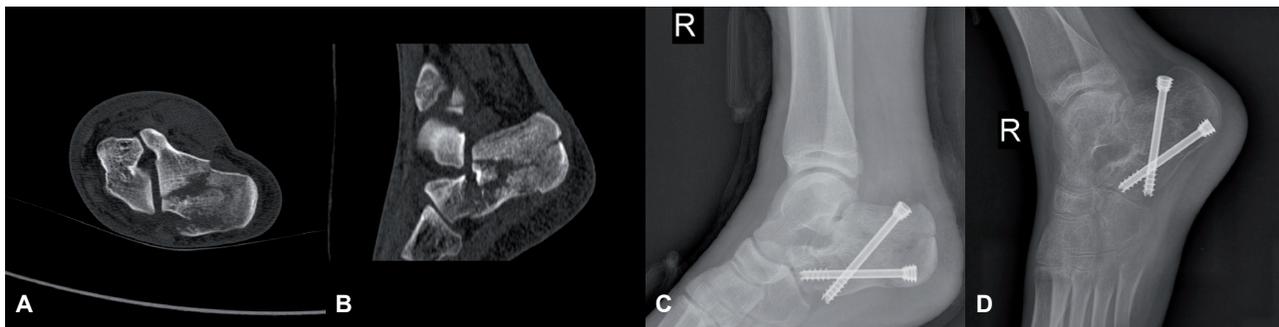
1A-1B, A 14-year-old boy who fell from a height induced to right calcaneus fracture (Sanders type IIA). 1C Immediate postoperative radiograph demonstrating restoration of Bohler's angle and Gissane's angle. 1D, Nine-month postoperative lateral radiographs showing a normal Bohler's angle and Gissane's angle and no evidence of subtalar joint osteoarthritis.
